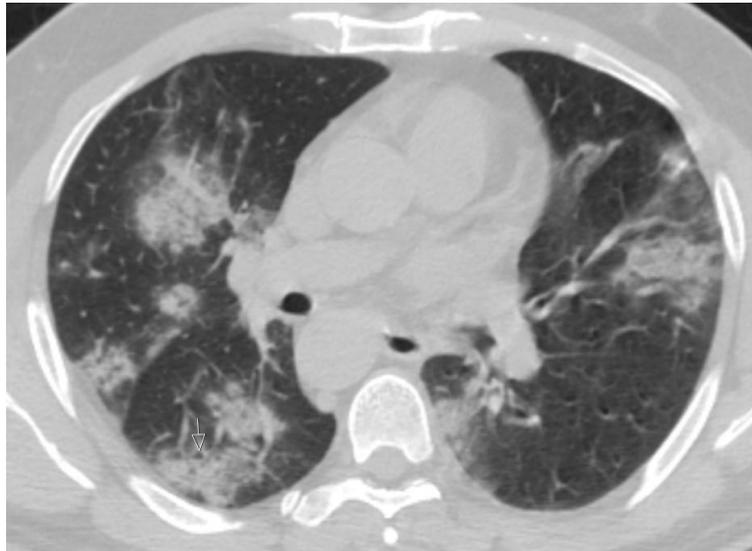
57-year-old man with COVID-19. Axial chest CT image shows peripheral and peribronchovascular distributed focal ground-glass opacity in both lungs (arrow).
